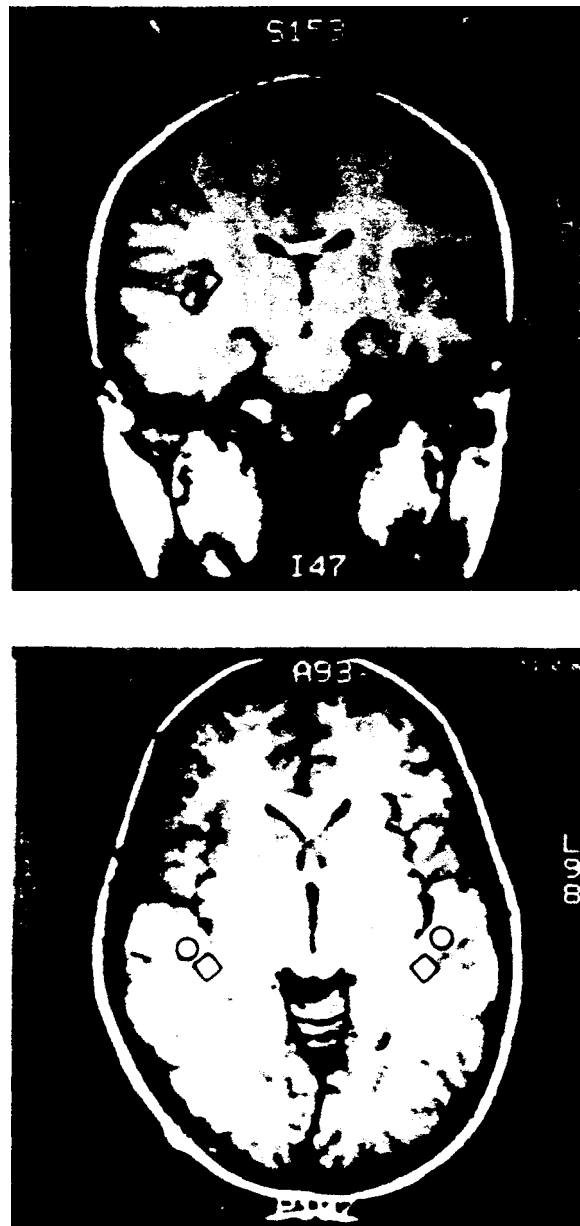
Coronal (Y Z) (*top*) and horizontal (X-Y) (*bottom*) MRI sections from subject DA with N1m (diamond) and Ndm (circle) centroid locations superimposed. Reproduced with permission from Arthur, Lewis, Medvick, & Flynn (1991).
